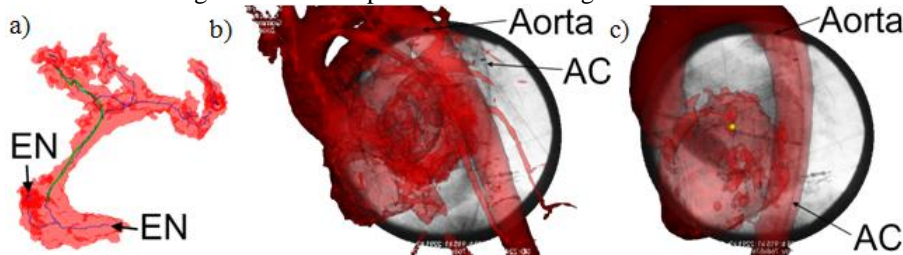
a) The CS (*red, translucent*) in the table coordinate system using the transformation found, with the skeleton (*blue*) and the catheter (*green*). The catheter may have entered from either points labeled *EN*. b) A model of the heart (*red, translucent*) overlaid on top of the intraoperative x-ray image using only the CS to constrain the registration. The segment of the aortic catheter (*labeled AC*) does not lie in the segment of the aorta. c) as b), except using both the CS and aortic catheter/vessel pairs, resulting in a more accurate registration.
